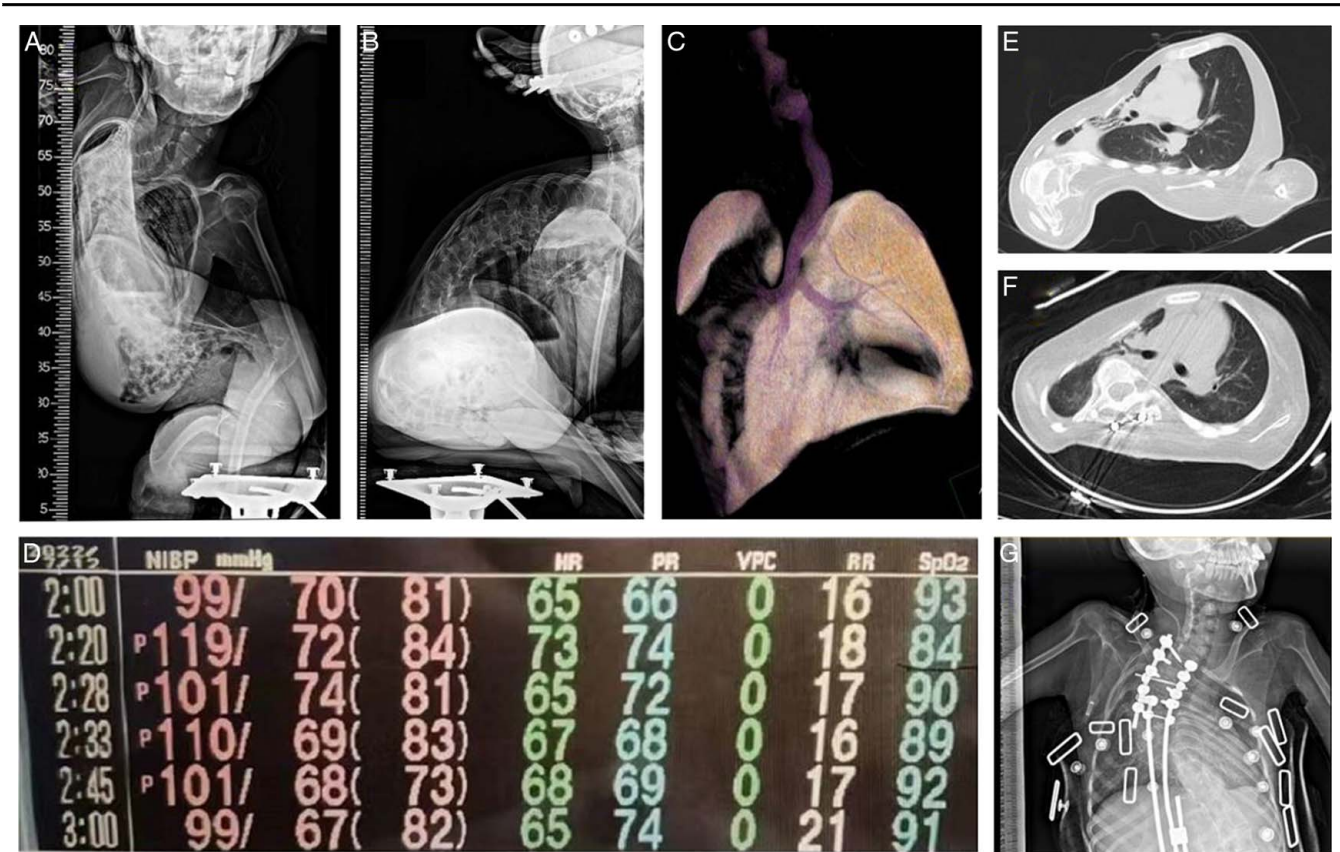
Typical case 2 A 16-year-old male spinal muscular atrophy patient with type II, whose Cobb's angle was 163° for scoliosis (A, E) and 128° for kyphosis (B). Preoperative three-dimensional Airway reconstruction showed thoracic and spinal deformity with right lung destruction (C). Pulmonary function showed a severe restrictive ventilatory dysfunction (FVC was 14% of predicted and FEV1 was 14.3% of predicted). Noninvasive ventilator was used at night and SPO₂ was less than 90% on average (D). He underwent posterior scoliosis correction under general anaesthesia and extubated when the operation is over. Then he was admitted to ICU for intensive care. Re-examination of chest X-ray showed that the thoracic deformity was significantly improved (F, G).
